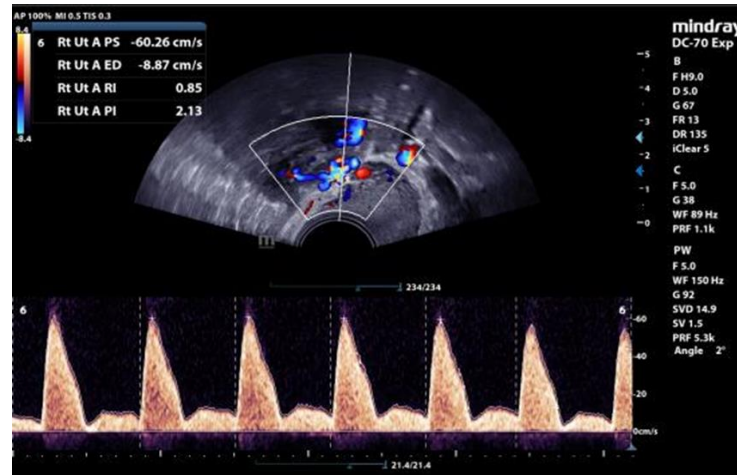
Doppler of uterine artery (RI :0.85, PI:2.13)
